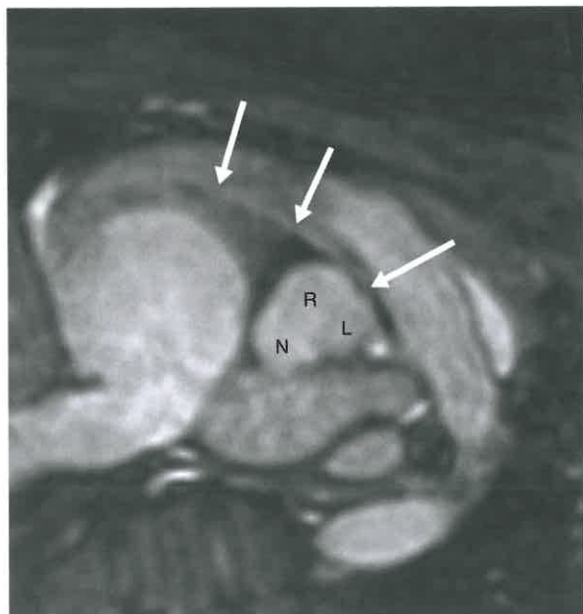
A 3D SSFP MRA of the coronary arteries in a 15-year-old boy with chest pain and an abnormal echocardiogram show an interarterial course of the RCA which is narrowed proximally (*white arrows*). Although there are advocates for using coronary MRA to assess for atherosclerotic coronary artery disease, most institutions use cMRA to assess for anomalous coronary arteries and coronary artery aneurysms, especially in the pediatric population or those with severe contrast allergies (*R, L, N* = right, left, and noncoronary sinuses, respectively).
